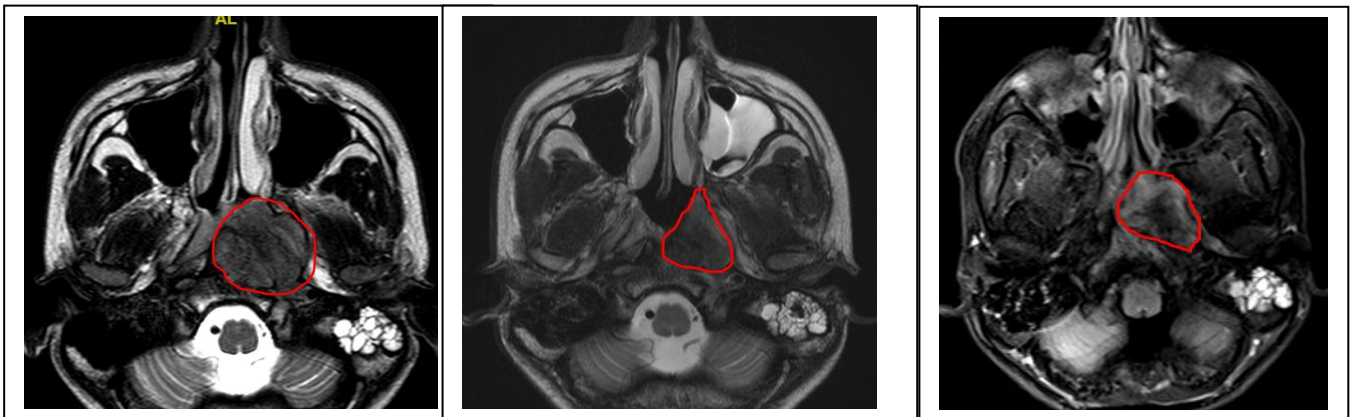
CT Imaging of a Partial responder showing primary lesion at Diagnosis
